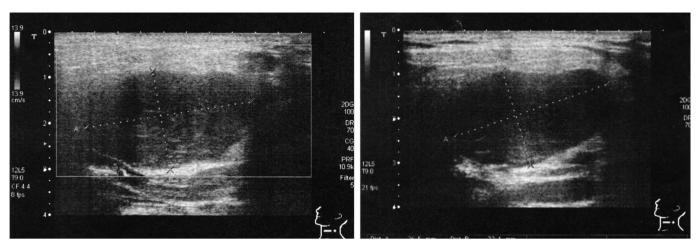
Ultrasound study performed with a linear probe, noticeable is the hypoechoic formation with vascular spots.
